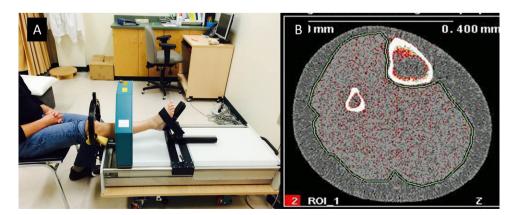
Peripheral quantitative computed tomography (pQCT) scanner (XCT2000, Stratec) with a participant positioned for lower extremity scanning (A). A representative cosssectional pQCT image (B) obtained at the 66% site of tibial length (large, white bone). The green outline between the light grey (muscle) and darker grey (subcutaneous fat) is the threshold defined border between tissues. Colours in the pQCT image (B) represent tissue densities, with dark grey (fat) being the lowest density and white (bone)being the highest density.
